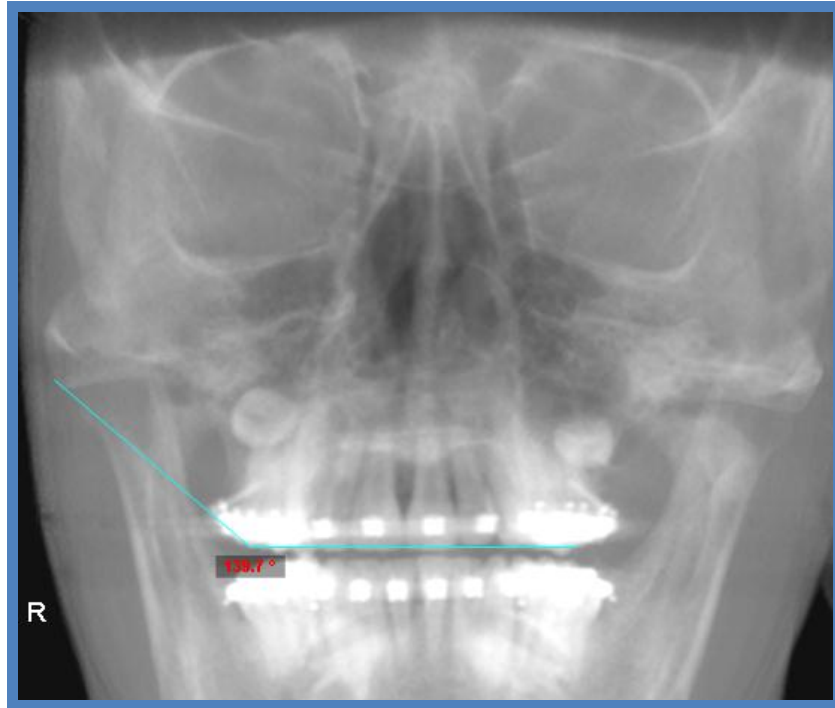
Example of an occlusal plane measure for the frontal view. Segmentation of the radiograph and placement of reference lines for localizing the mesio-buccal cusp tips of both maxillary first molars was completed prior to the final measurement of the angle to the zygomatic arch. This image is from an initial CBCT scan with brackets in place.
